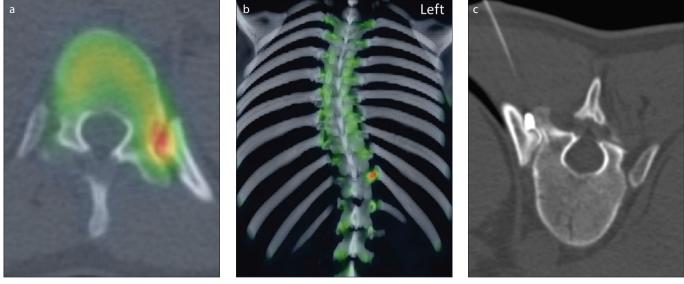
a–c. SPECT-CT images of a 17-year-old girl (case 7) with left lower thoracic back pain and increased technetium-99m methylene diphosphonate (^{99m}Tc MDP) activity. Panel (a) shows increased bone tracer activity at the left 11th costovertebral joint. Posterior volume-rendered reformatted image (b) shows that no alternative pain generator with increased ^{99m}Tc MDP activity is present. Note the presence of scoliosis without associated increased ^{99m}Tc MDP activity. The joint was injected with 4.5 mg betamethasone and local anesthetic (c). The patient had no pain relief after injection.
